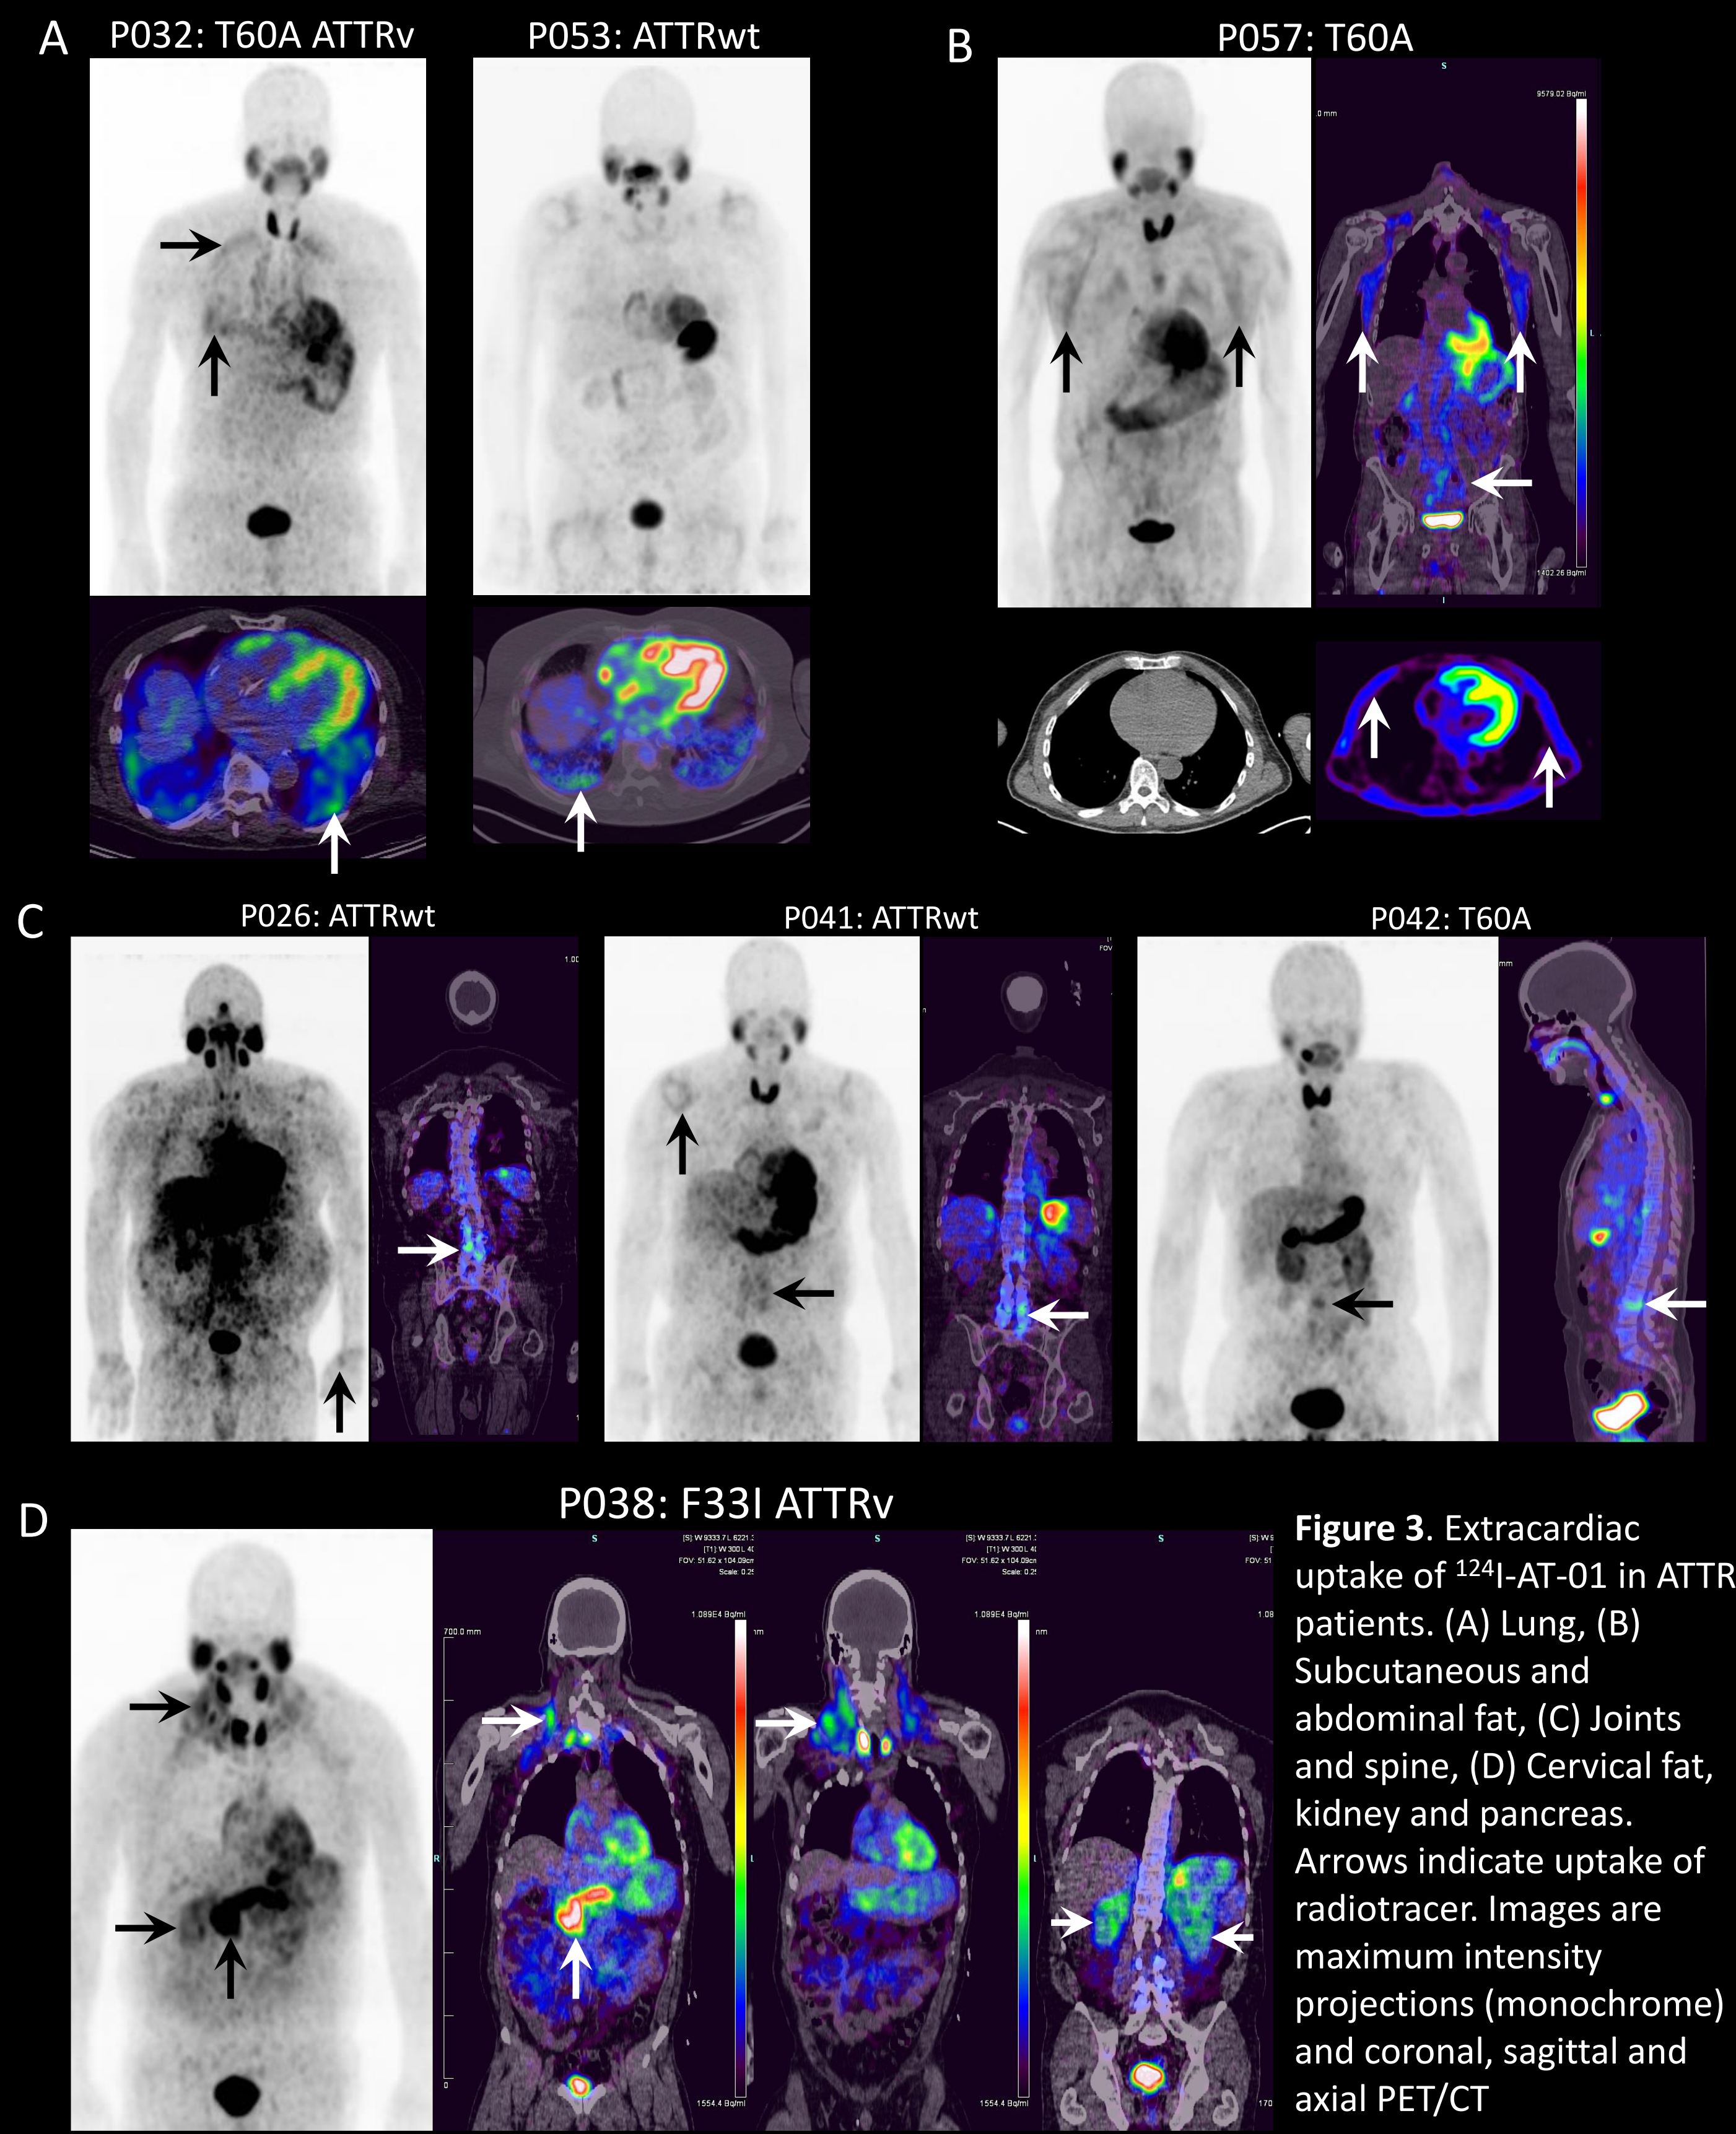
Extracardiac uptake of ¹²⁴I-AT-01 in ATTR patients. (A) Lung, (B) Subcutaneous and abdominal fat, (C) Joints and spine, (D) Cervical fat, kidney and pancreas. Arrows indicate uptake of radiotracer. Images are maximum intensity projections (monochrome) and coronal, sagittal and axial PET/CT
